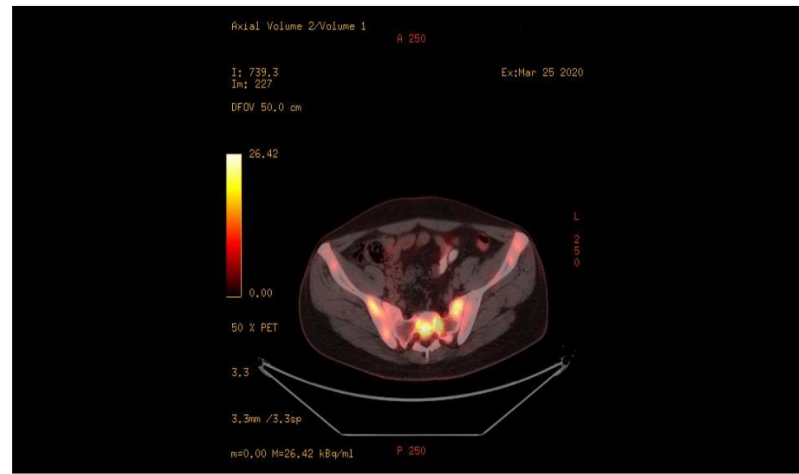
Diffuse involvement areas of lymphoma in the iliac bone and sacroiliac joint seen in PET-CT taken five months after the diagnosis of axial spondyloarthritis.
